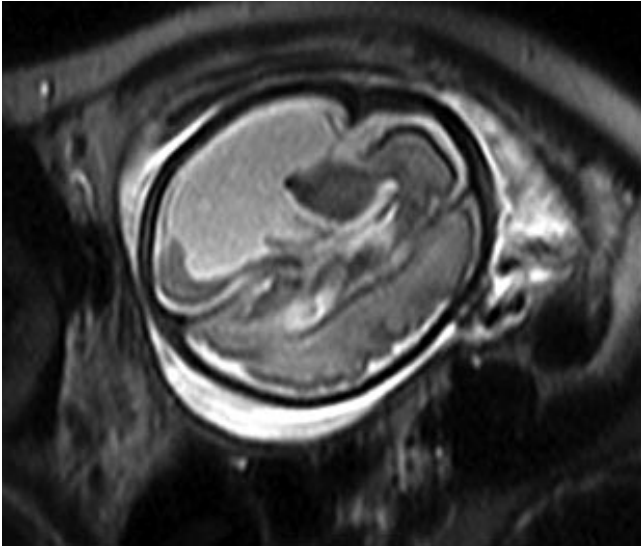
Axial prenatal MRI demonstrating unilateral left 'porencephalic cyst'.
